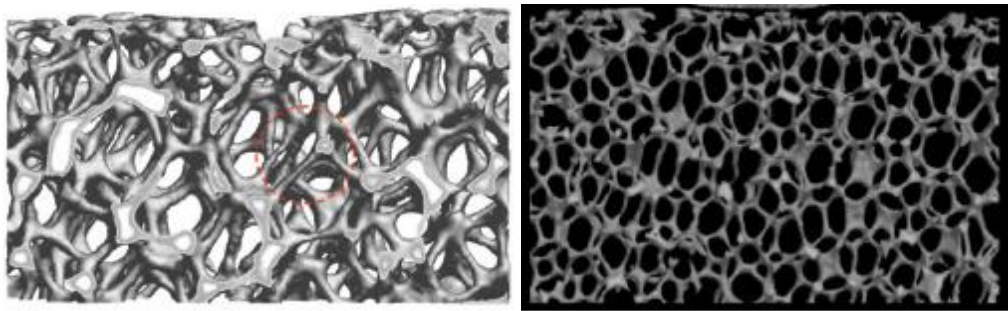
Renderings from μ CT data showing porous structure and internal pattern of vertebral trabecular bone (left) and aluminium foam (right) which make the materials ideal for DVC (292).
